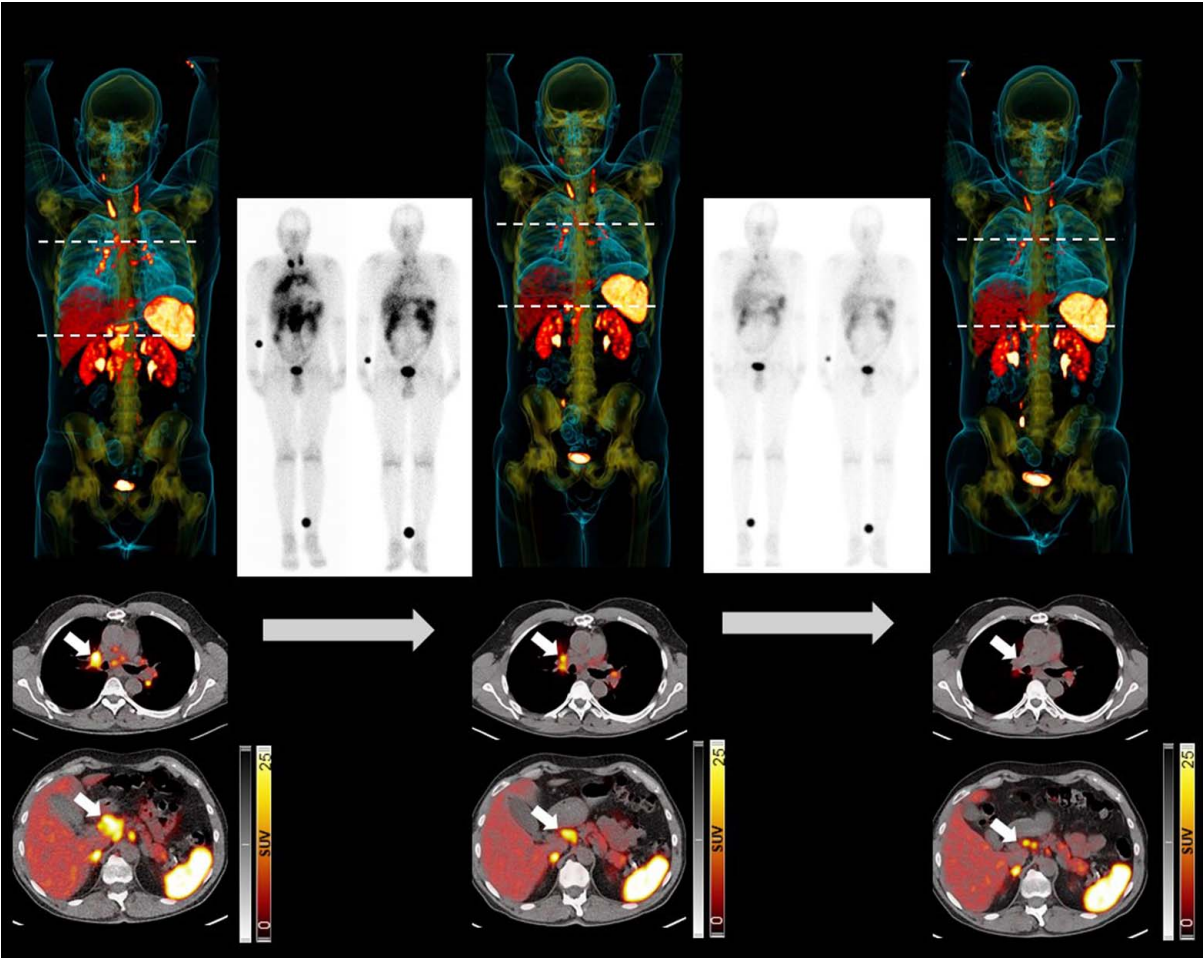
A 59-year-old man with esthesioneuroblastoma, classified as Kadish grade D and Hyams grade 3 with partial response upon first restaging (after 2 cycles of PRRT) and second restaging (after 2 more treatment cycles). Maximum intensity projections of SSTR-directed PET/CT and transaxial views are displayed on the left (at baseline before therapy), middle (restaging after 2 cycles of PRRT) and right (restaging after 2 more cycles). Posttherapeutic whole-body (WB) planar scintigraphy between restagings in the anterior views are also displayed (inserts). Left: at baseline, the patient presented with SSTR-positive pulmonal and lymph node lesions (arrows). Middle: after 2 cycles of PRRT, the patient showed partial response with a decrease in the size of lesions on SSTR-targeted PET/CT (arrows). Right: after 2 more cycles, the subject presented with a further decline of target lesions upon restaging with PET/CT (arrows). WB planar views right after the first and second cycles (insert, left) showed intense uptake after injection of the ¹⁷⁷Lu-labeled, SSTR-positive radiotherapeutic, which further decline of uptake after the third and fourth cycle (insert, right), which was most likely due to a decrease in tumor size under treatment.
